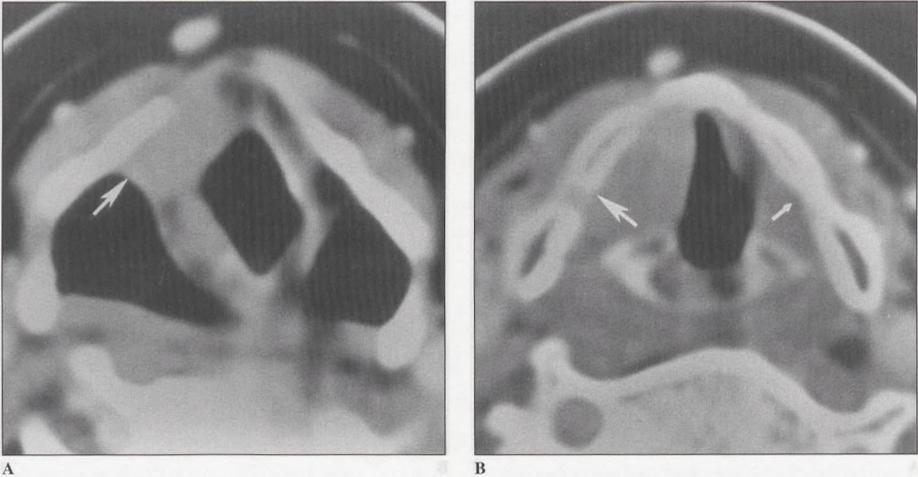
CT scan of a patient with a 2.1-cm³ carcinoma of the right true vocal cord and a tumor score of 4. (A) Image just above the false cord level demonstrates involvement of the right aryepiglottic fold and obliteration of the paraglottic space (arrow). (B) Image at the true vocal cord level demonstrates involvement of the entire cord which is in paramedian position. The ipsilateral paraglottic space is obliterated (large arrow), compared to the contralateral paraglottic space (small arrow) without anterior commissure involvement or posterior spread. Subglottic extension (not shown) was also present. The patient is alive without evidence of disease 31 months after the completion of radiotherapy.
